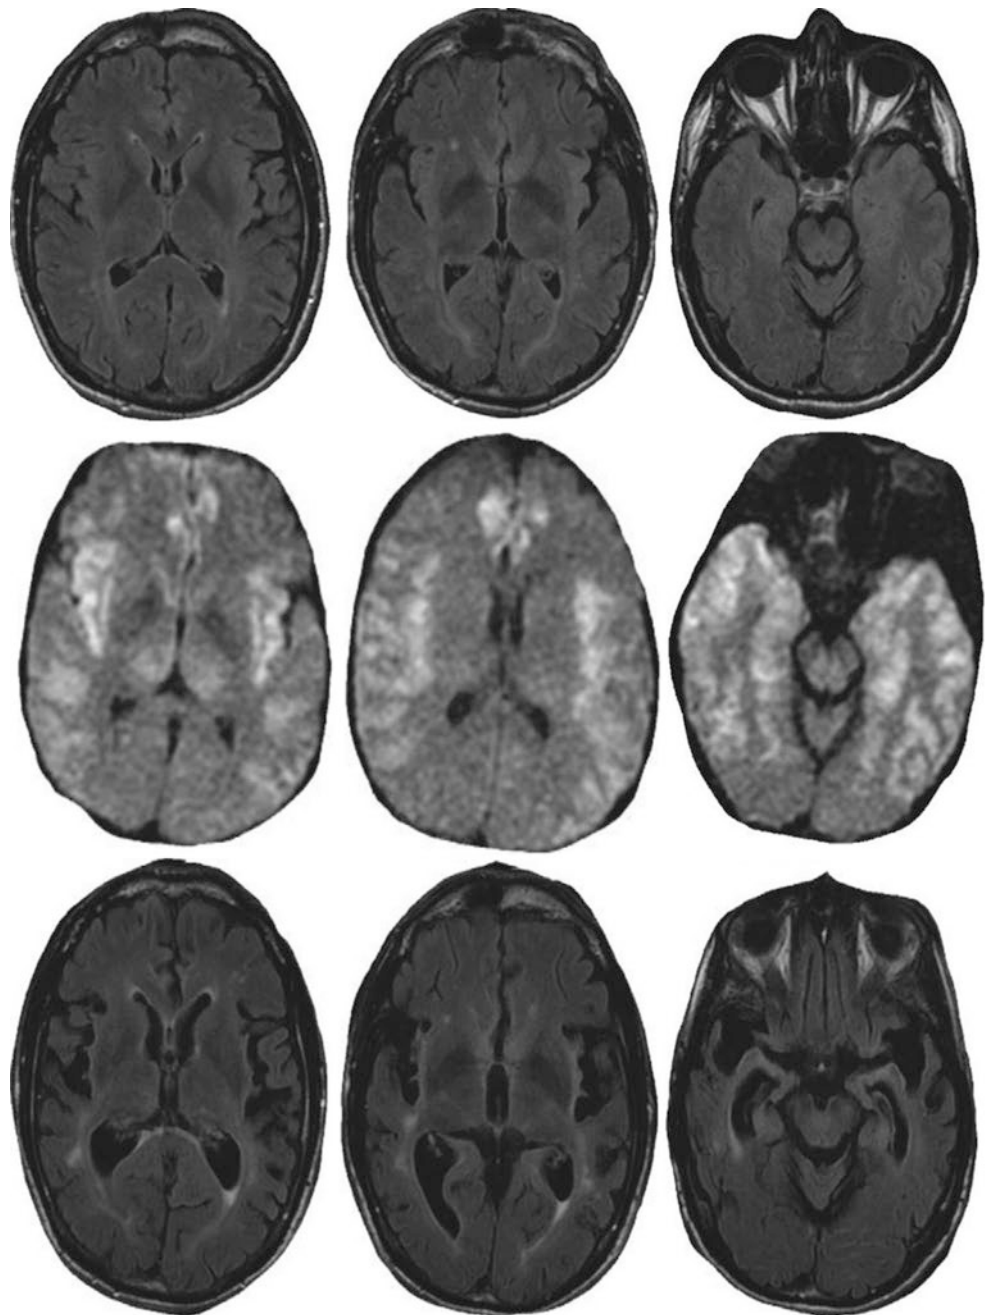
MRI features of hyperammonemia in a patient with liver failure. A 49-year-old man with hepatitis C, MELD score 17, with accidental chronic acetaminophen overdose, SOFA score 11, and peak plasma NH₃ level of 606 mmol/L. Plasma ammonia level was <100 mmol/L for 6 days. (*Top*) Baseline outpatient MRI findings 6 months prior for headache workup. (*Middle*) Diffusion weighted images during admission for liver failure. DCRD involving bilateral cingulate gyrus, insular cortex, temporal lobes, frontal lobes, and posterior thalamus. (*Bottom*) Cortical atrophy matching areas of restricted diffusion on 9-month follow-up MRI. Moderate-to-severe static cognitive impairment (From Kandiah PA, Pandya D, Lynch JR, et al. Catastrophic hyperammonemia: a case series. *Neurocritical care* 2008;8(1):61–232; and Kandiah PA, Pandya D, Nanchal R, et al. Metaanalysis of magnetic resonance imaging findings and neurological outcomes in liver failure and severe hyperammonemia. In: 15th International Society for Hepatic Encephalopathy and Nitrogen Metabolism: 2012. Grenaa, Denmark, 2012. pp. 25–6; with permission.)
